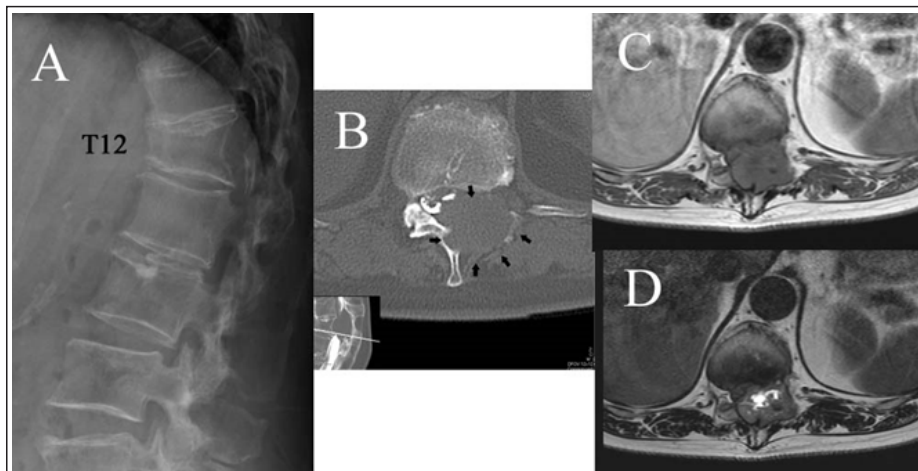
(a) A lateral plain X-ray showing an old compression fracture of the 12th vertebral body. (b) An axial computed tomography-myelography showing that the expansile tumor involves the left lamina and the base of the spinous process of the T12. The thecal sac was remarkably compressed by the tumor. (c) An axial T1-weighted magnetic resonance imaging (MRI) showing a tumor within the left posterior element that is of an intermediate signal. The part of the central portion of the tumor shows a low signal compared to the muscle. (d) In an axial T2-weighted MRI, the tumor shows a heterogeneously high signal compared to the muscle. The low signal area in the T1-weighted image shows marked high intensity.
